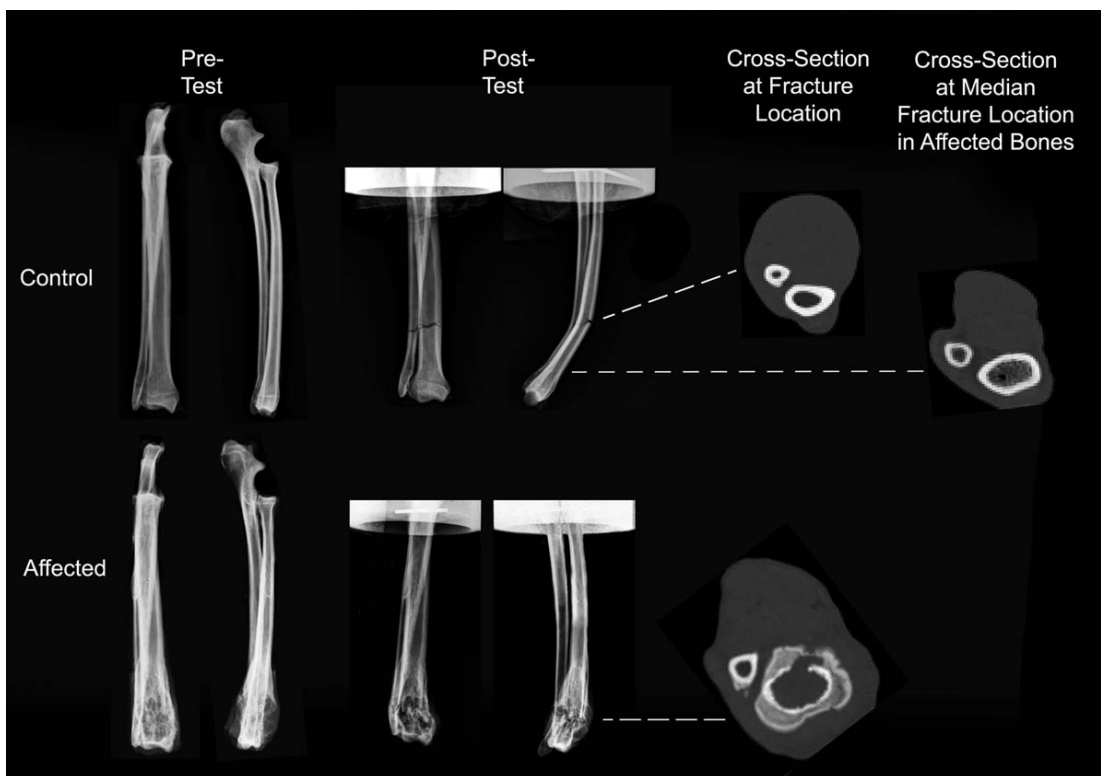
Radiographs representative of pre-test and post-test fracture location in OSA-affected and unaffected control bones. Cross-sections of the bones were obtained at the fracture site. A cross-section of the control bone taken from the median location of the fracture in OSA-affected bones is also shown
